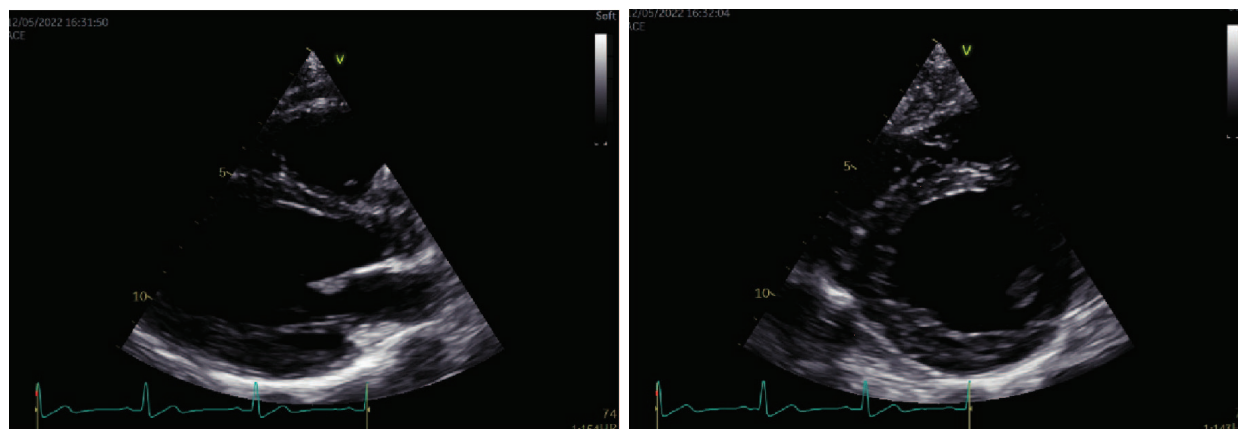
Parasternal long axis view and short axis view and strain imaging measurements
